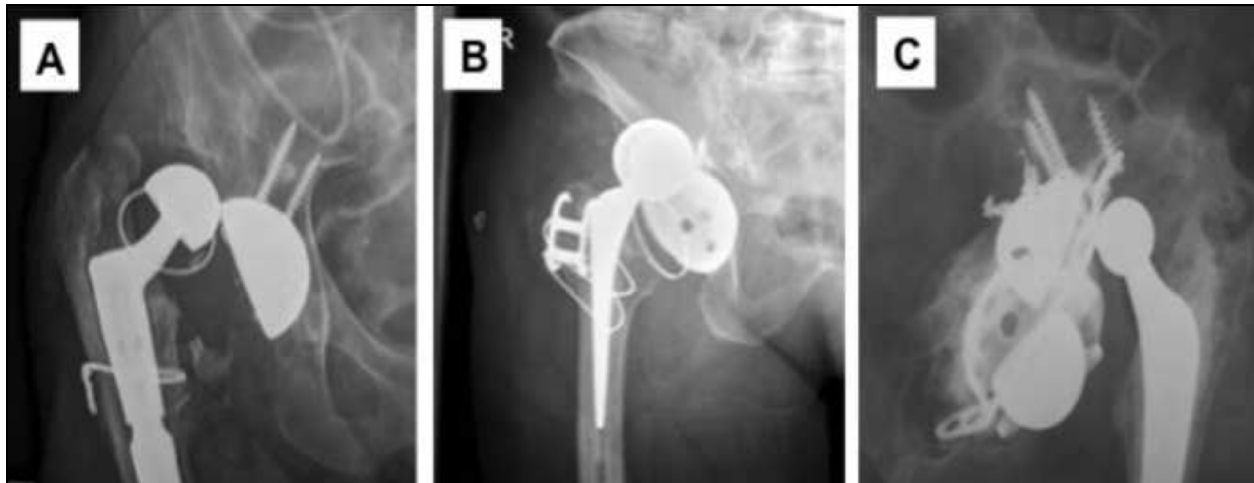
Radiographs (AP hip) of the 3 patients who dislocated post-operatively. (A) Type II failure at the mechanism holding the constrained liner to the outer metal shell, (B) Type III failure of the retaining mechanism of the bipolar component and (C) Type IV dislocation of the prosthetic head at the inner bearing of the bipolar component.
